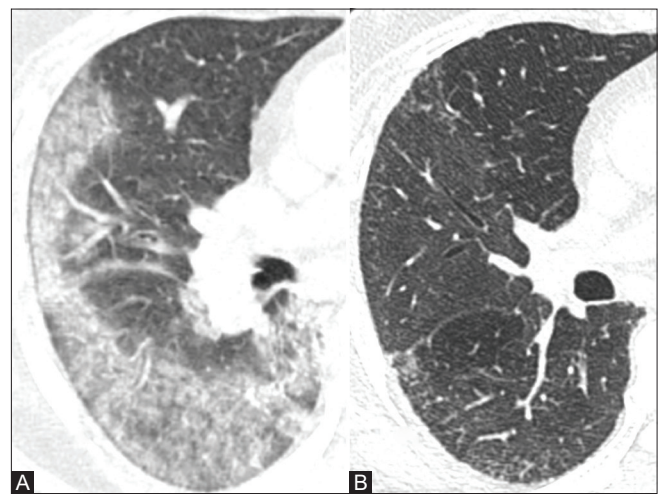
(A and B): HRCT (A) demonstrates ground-glass densities/consolidations in subpleural region. Follow up CT (B) after 15 days reveals total clearing of abnormalities
